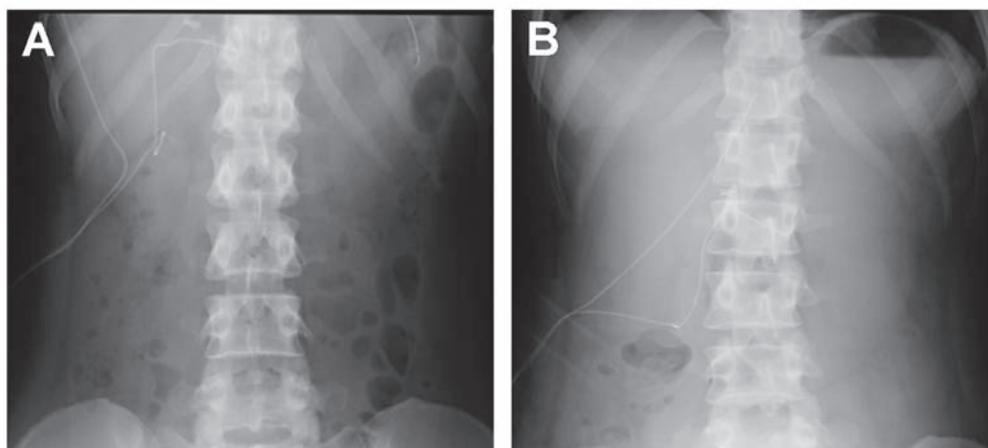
X-ray obtained after surgery. (A) A drainage tube was placed in the right subphrenic space (arrow head) postoperatively. (B) The tube is displaced to the left side by the huge hematoma on postoperative day 1.
